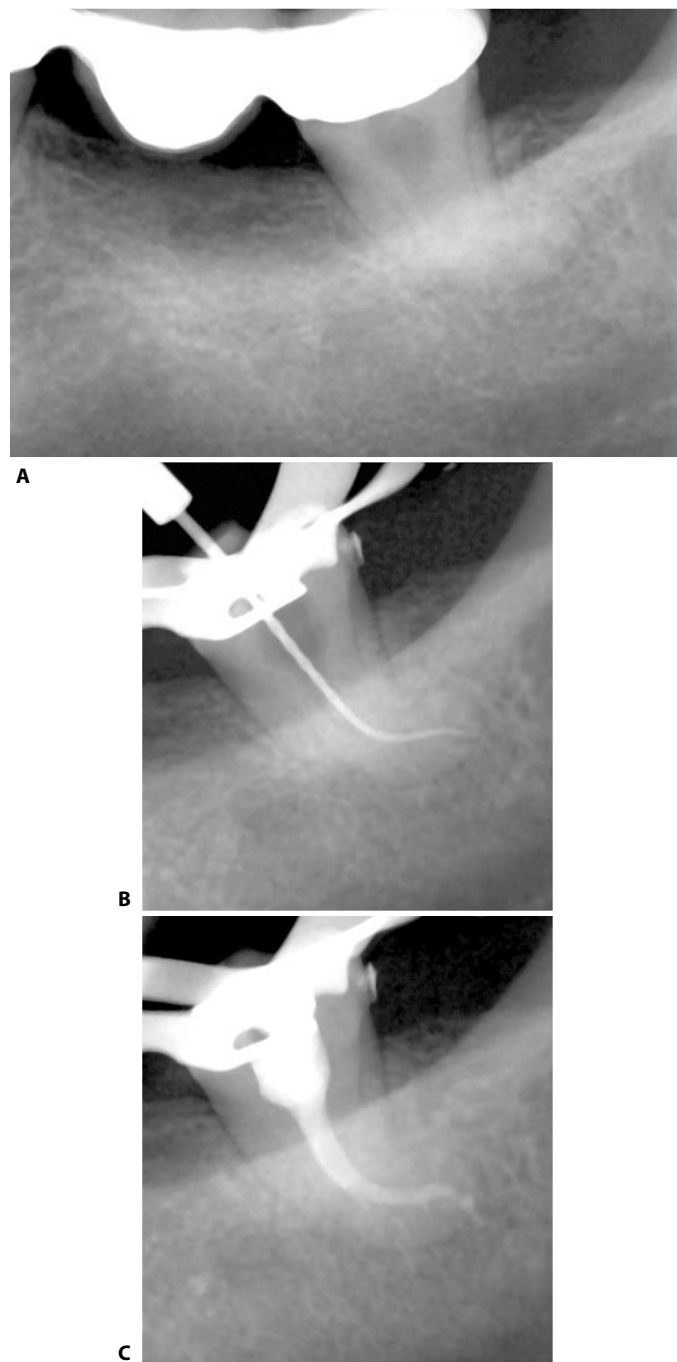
Endodontic treatment of a lower third molar. A. Preoperative radiograph: the tooth presents with a single canal having a rather accentuated double curvature. B. Intra-operative radiograph. The canal preparation was carried out with NiTi instruments (Quantec Analytic, Glendora, CA, USA). C. Postoperative radiograph. For the obturation a condenser with .02 conicity and # 25 tip diameter was preferred because it was more flexible.
